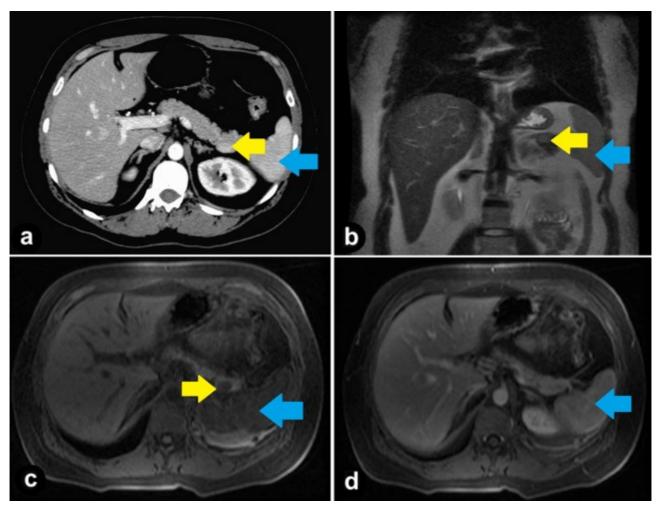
a. Contrast-enhanced axial CT Scan showing intra-pancreatic lesion in the tail of the pancreas isoattenuating compared to spleen. b. Coronal T2-haste MR image showing intra-pancreatic accessory spleen with signal intensity similar to that of the spleen. c. Axial pre-contrast T1-weighted MRI with fat saturation showing hypointense signal of intrapancreatic accessory spleen relative to the pancreas. d. Axial gadolinium T1-weighted MRI, portovenous phase (notice that intrapancreatic accessory spleen becomes homogenously isointense relative to surrounding pancreatic parenchyma, nearly obscuring the lesion).
